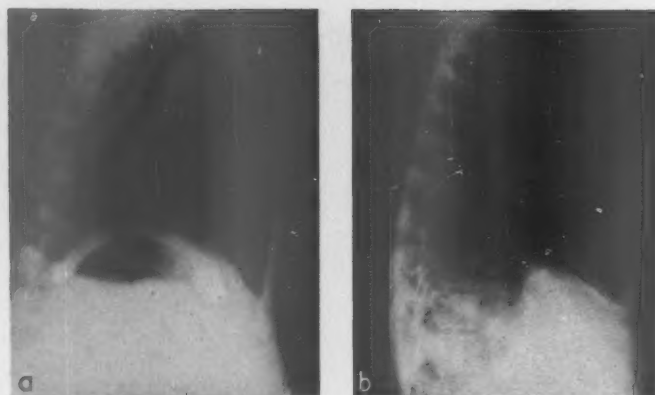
(a) Lateral radiograph showing a large subdiaphragmatic abscess after aspiration and instillation of air. (b) Five weeks later, after the abscess had ruptured into the thoracic cage. Pus tracking up the greater fissure. Death followed a biliary-bronchial fistula
